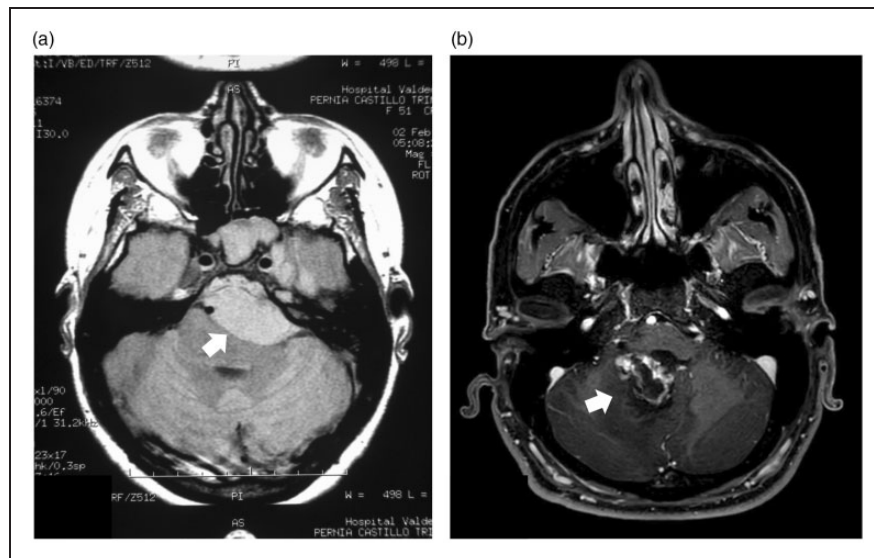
Two examples of MRI with structural posterior fossa lesions (arrows) in patients consulting due to cough headache. (a) one extrinsic meningioma and (b) one intraparenchymal subependymoma. Both patients showed nystagmus and instability.
